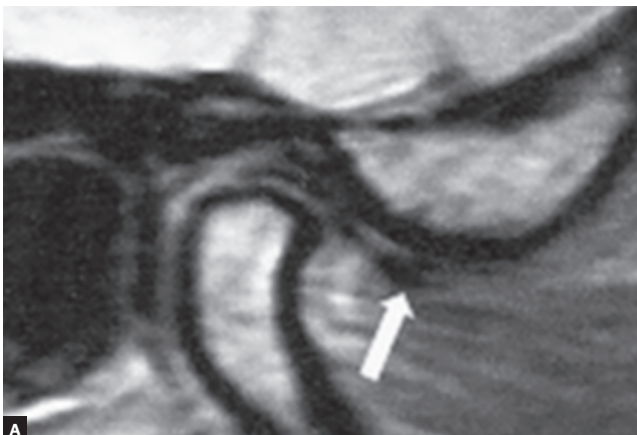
A) MRI sagittal slice of the right TMJ with the mouth closed, evincing the persistence of TMJ articular disc displacement. B) MRI sagittal slice of the right TMJ at maximal mouth opening, evincing reduction of TMJ articular disc.
